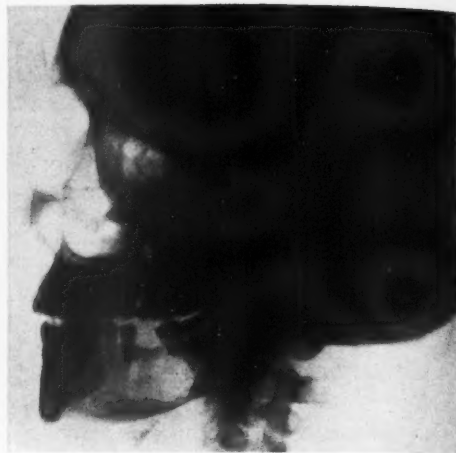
Roentgenogram of a central fibroma of the lower jaw. This diagnosis was made only at operation by the aid of frozen sections. Path. No. 42,680.
